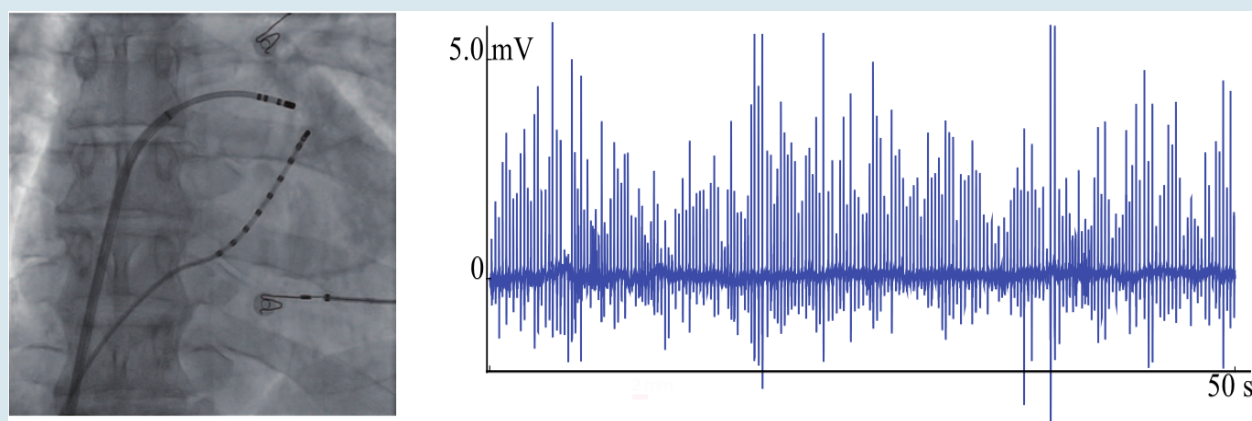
(Left) Radiography of atria showing catheters. (Right) Turbulent like temporal series of a complex atrial arrhythmia.
